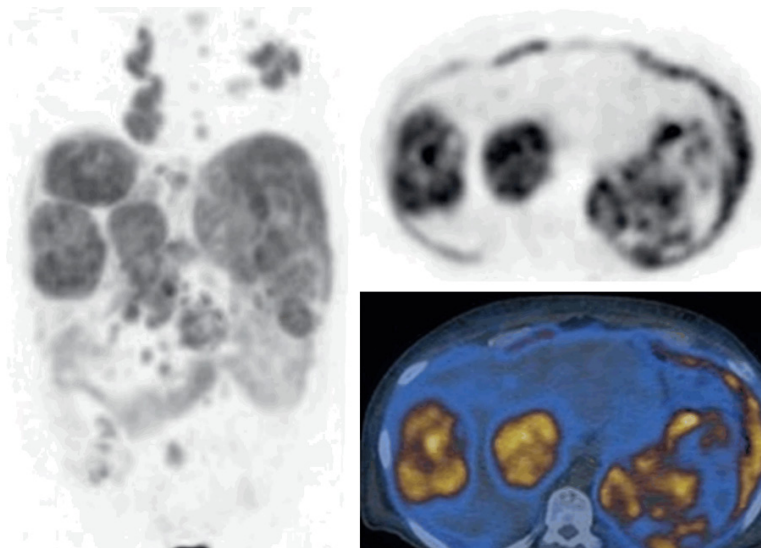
FDG PET/CT images of a case with lymphomatous involvement of the liver due to diffuse large B cell lymphoma (body MIP, selected transaxial PET and PET/CT fusion images of the liver). Large hypermetabolic masses in the liver (SUVmax: 19) with diffuse involvement of the spleen and multiple hypermetabolic lymph nodes in the chest and abdomen.
